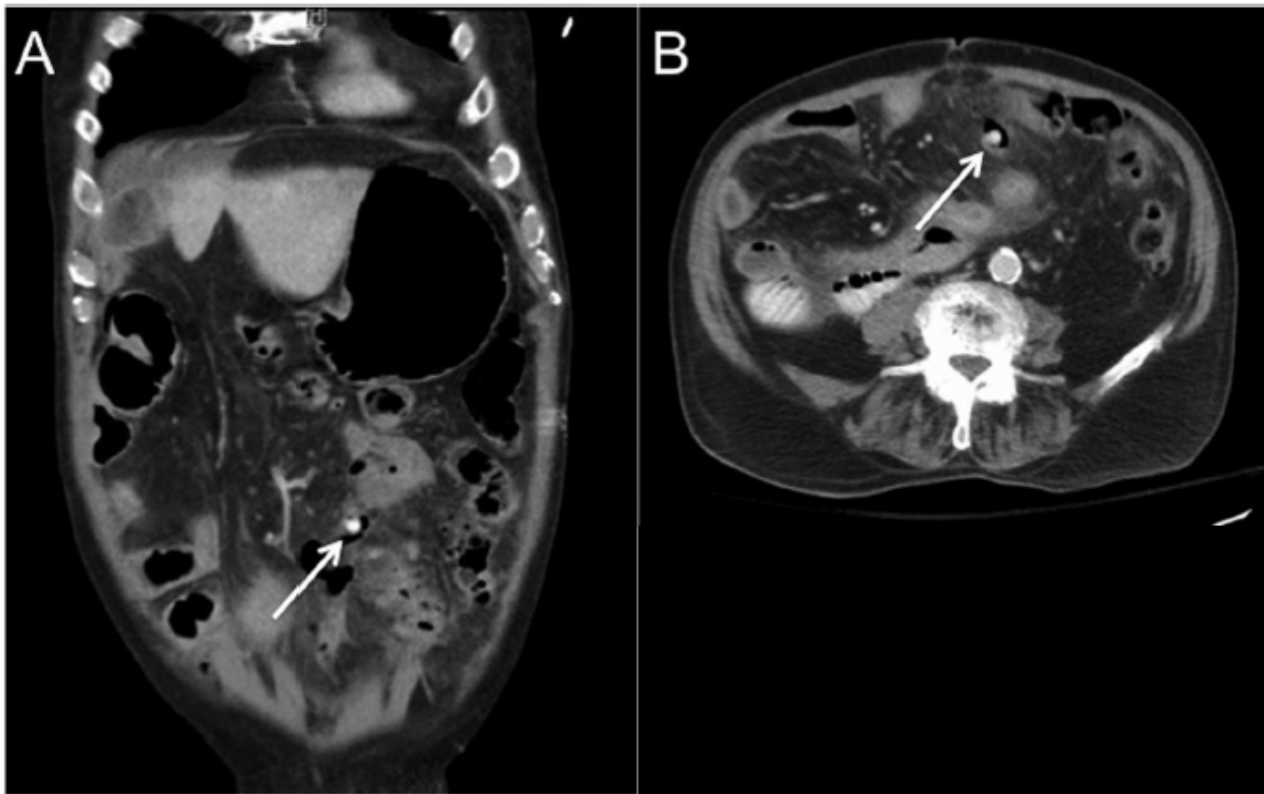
Abdominal Computed Tomography (CT). Abdominal CT shows thickened loops of bowel in the mid-abdomen with a prominent fecalith (white arrow). The right colon is absent from its normal anatomic position.
